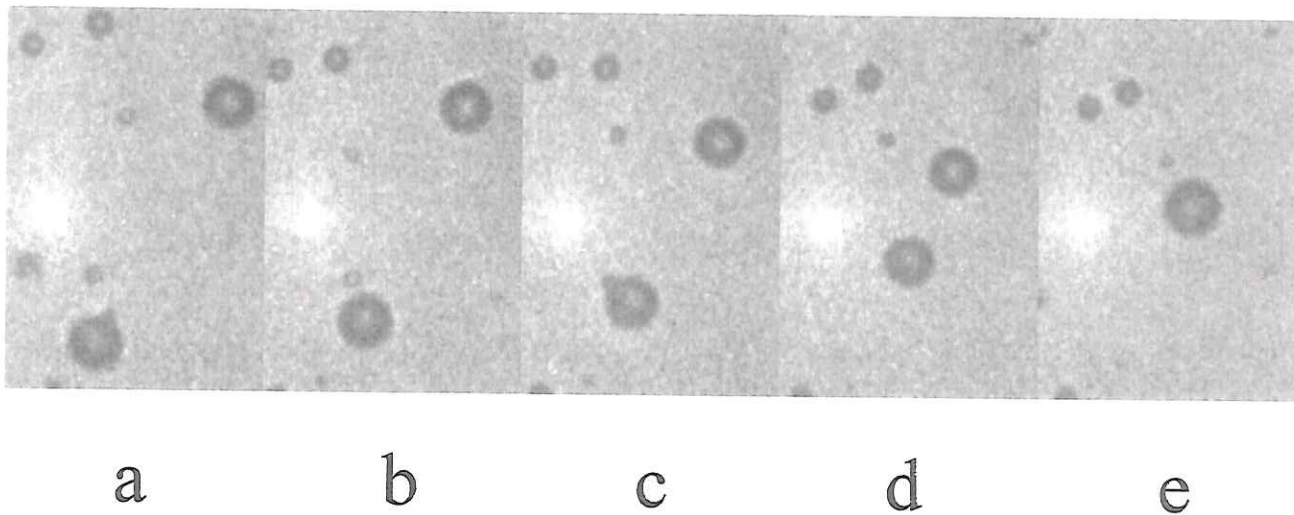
The approach of two  $\varnothing 4 \mu\text{m}$  experimental contrast bubbles induced by a secondary radiation force. Each image frame corresponds to a  $30 \times 20 \mu\text{m}^2$  area. Frames are each captured after insonification by 10 cycles of 0.5 MHz ultrasound ( $MI = 0.67$ ). © 2004 World Federation for Ultrasound in Medicine & Biology. Reprinted from Postema M, van Wamel A, Lancée CT, de Jong N. Ultrasound-induced encapsulated microbubble phenomena. *Ultrasound Med Biol* 2004 30(6):827–840.
